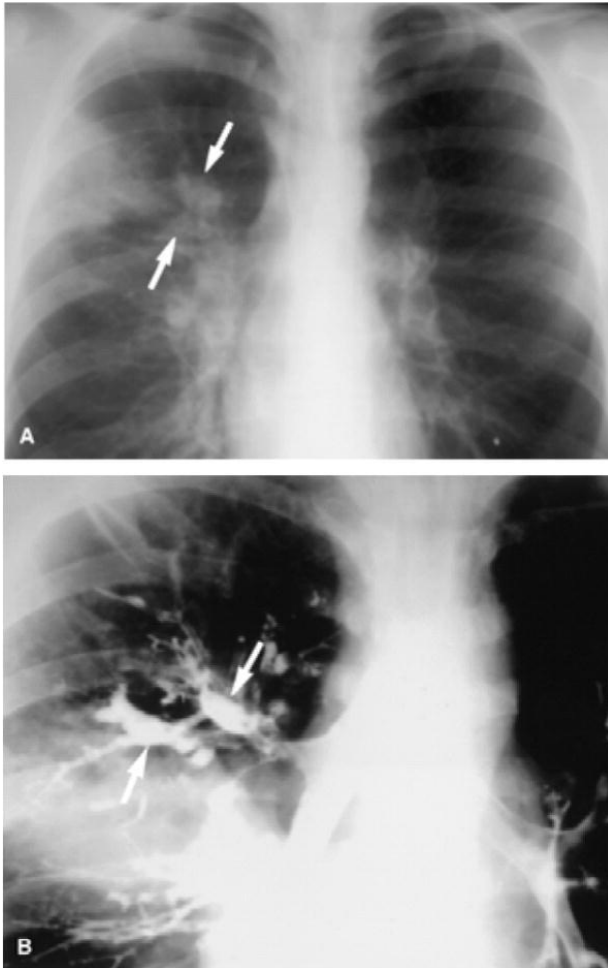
Allergic bronchopulmonary aspergillosis. A. Frontal chest radiograph reveals tubular opacities consistent with impacted bronchi (arrows) as well as right upper lobe consolidation. B. Bronchography in same patient reveals dilated bronchi (arrows) in the same distribution as seen on the chest radiograph [4].
